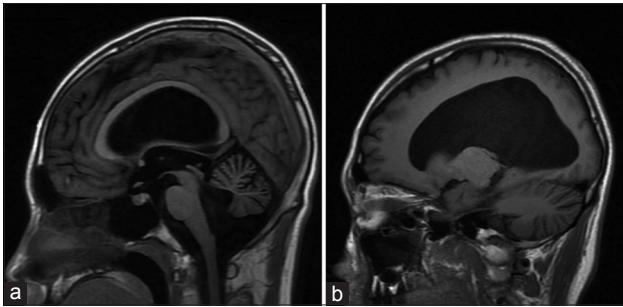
Axial T1-weighted brain magnetic resonance imaging results. It demonstrates the (a) hypoplasia of cerebellum and enlarged fourth ventricle and (b) hydrocephalus findings of characteristics of Dandy-Walker malformation.
